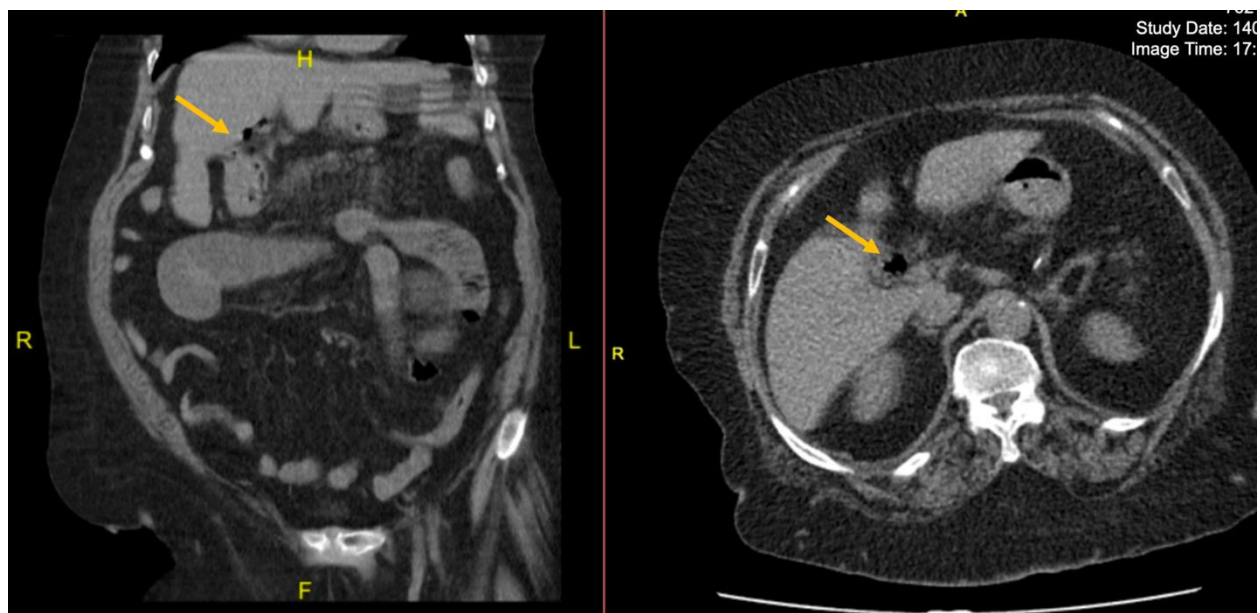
Preoperative CT scan of the patient revealed the presence of air bubbles within the gallbladder (yellow arrow), suggesting the formation of a biliary-duodenal fistula, although the gallstone itself was not visualized.
